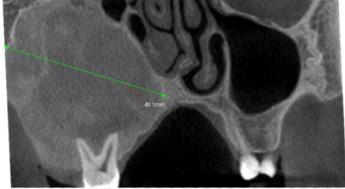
CBCT (axial view)
